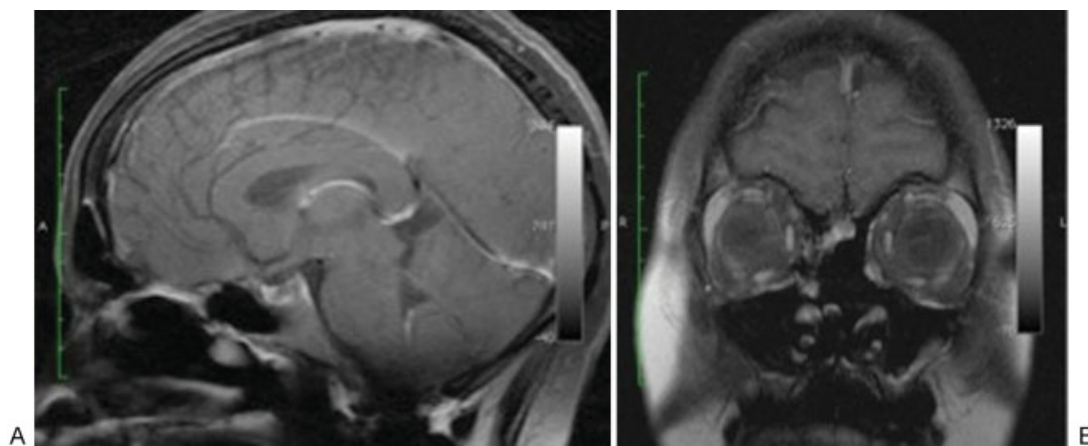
(A) Sagittal and (B) coronal T1-weighted postcontrast magnetic resonance imaging at 18 months postoperatively showing resection of the bony nasal septum, portions of the middle nasal turbinates, ethmoidal air cells, and the medial wall of the left maxillary antrum. No evidence of tumor recurrence is visible.
